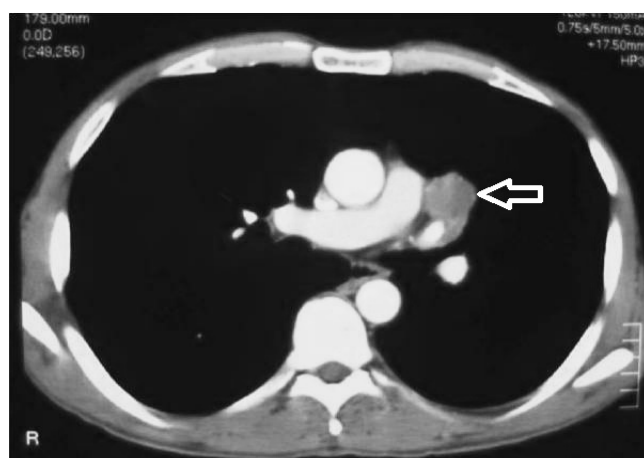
A contrast enhanced computed tomography (CT) scan was performed which showed a 3x3 cm sized mass (arrow) in the left lower lobe that did not involve the mediastinal structures.
